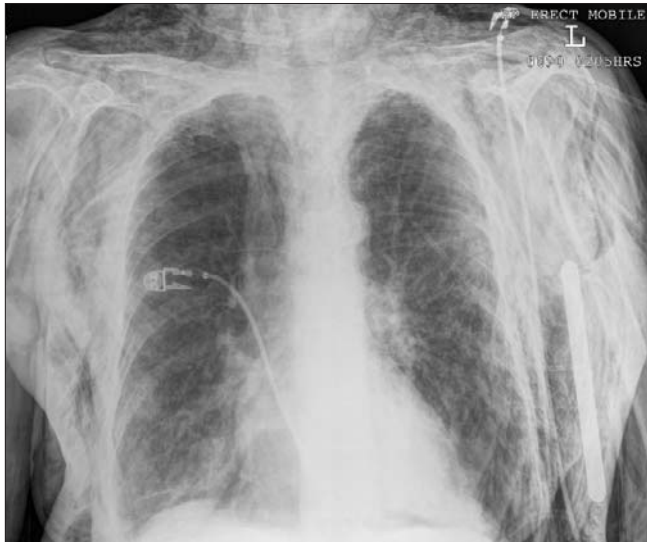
Chest x-ray, taken after opening the Heimlich valve, showing resolution of the tension pneumothorax but extensive subcutaneous emphysema
